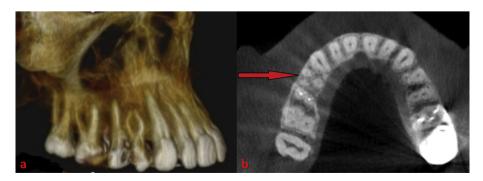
a. Three-dimensional cone-beam computed tomographic (CBCT) image of tooth #14 showing two buccal roots b. Axial view of the CBCT images of tooth #14 showing three roots.
